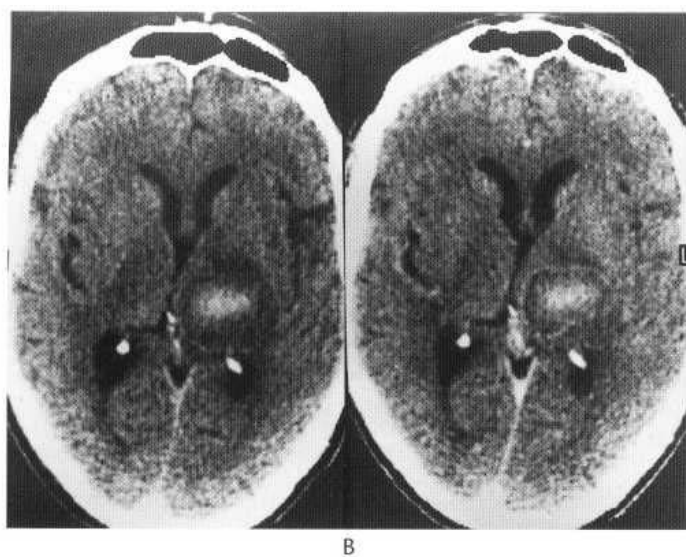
CT of resolving left thalamic haemorrhage 10 days after onset. (A) Before contrast there is some residual high density centrally. (B) After contrast there is marginal enhancement.
